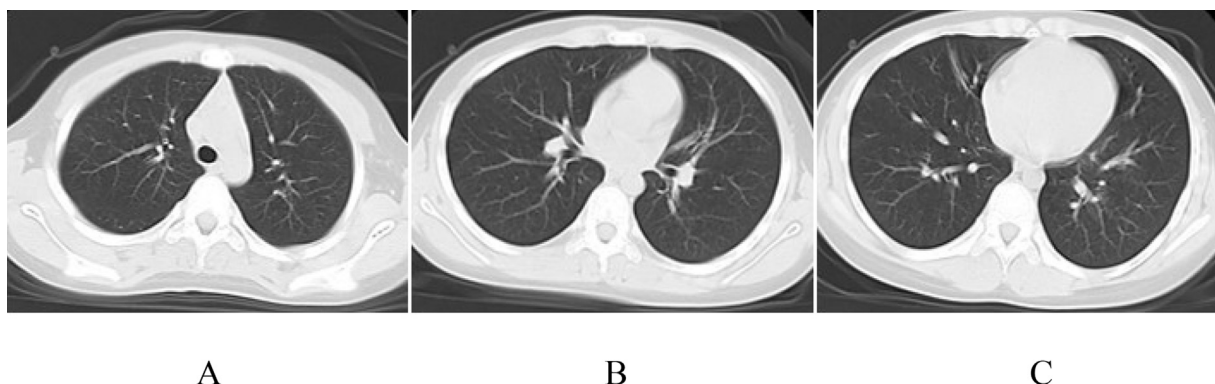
Chest CT images on the third and fifth days after admission showed no obvious changes in the bilateral lung.
